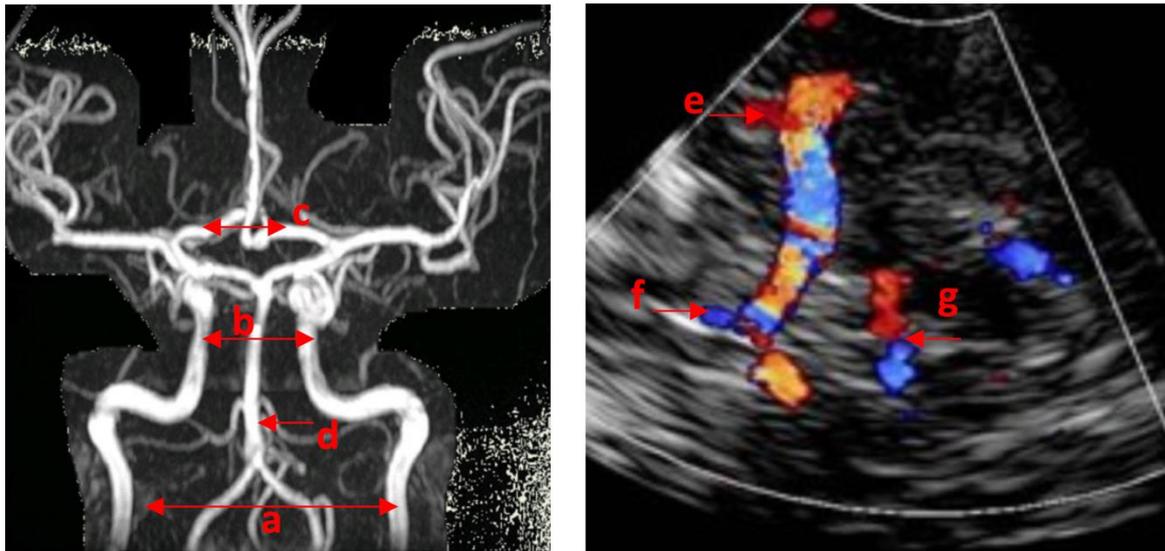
Circle of Willis cerebral blood vessels imaged using phase-contrast (PC) angiography (left) and transcranial colour Doppler (TCCD) (right). PC angiography image shows the carotid artery (a), internal carotid arteries (b), middle cerebral arteries (c), basilar artery (BA) and connecting macro- and micro-vessels. The TCCD image shows the middle cerebral artery (e), anterior (f) and posterior (g) cerebral artery.
